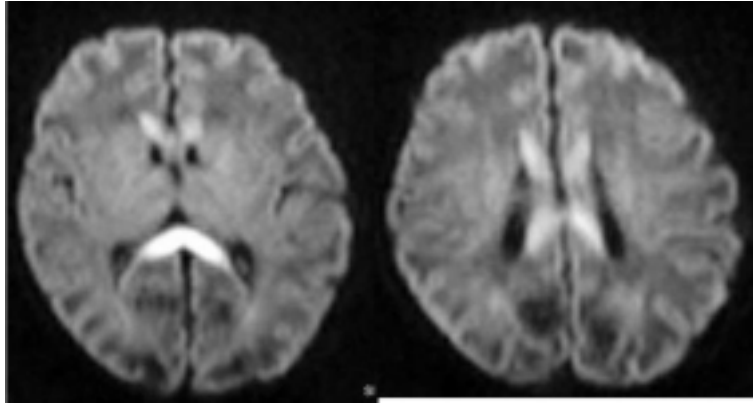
Diffusion-weighted magnetic resonance imaging on postnatal day 17 disclosing a high intensity lesion occupying the entire corpus callosum.
